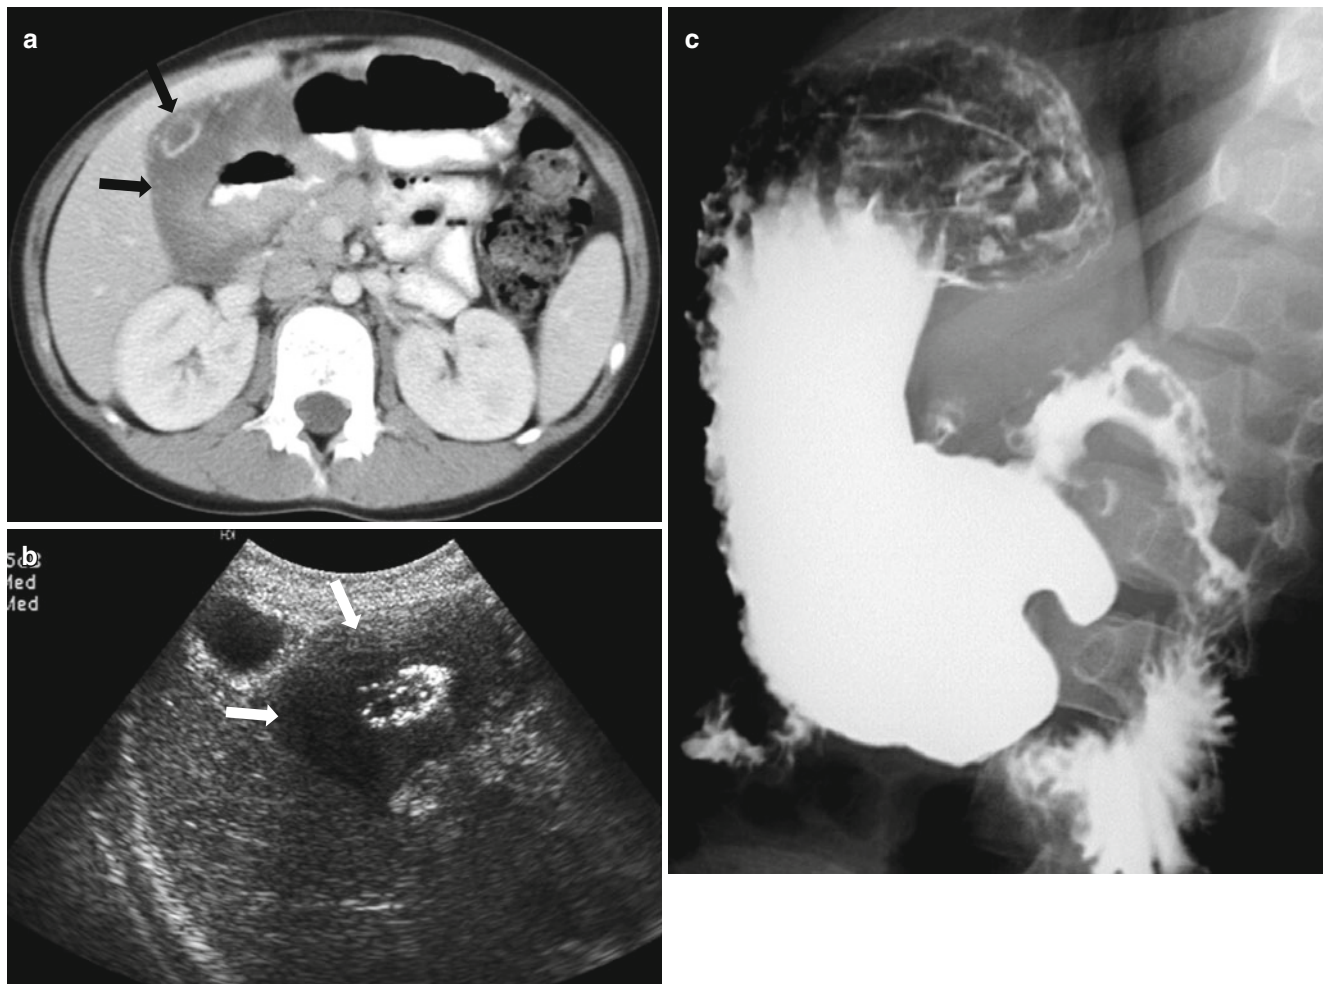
Burkitt lymphoma with bowel involvement. (a) Contrast-enhanced CT of a 4-year-old boy presented with abdominal pain and vomiting shows hypoattenuating, diffuse wall thickening involving duodenal bulb and second portion of the duodenum (arrows). (b)
